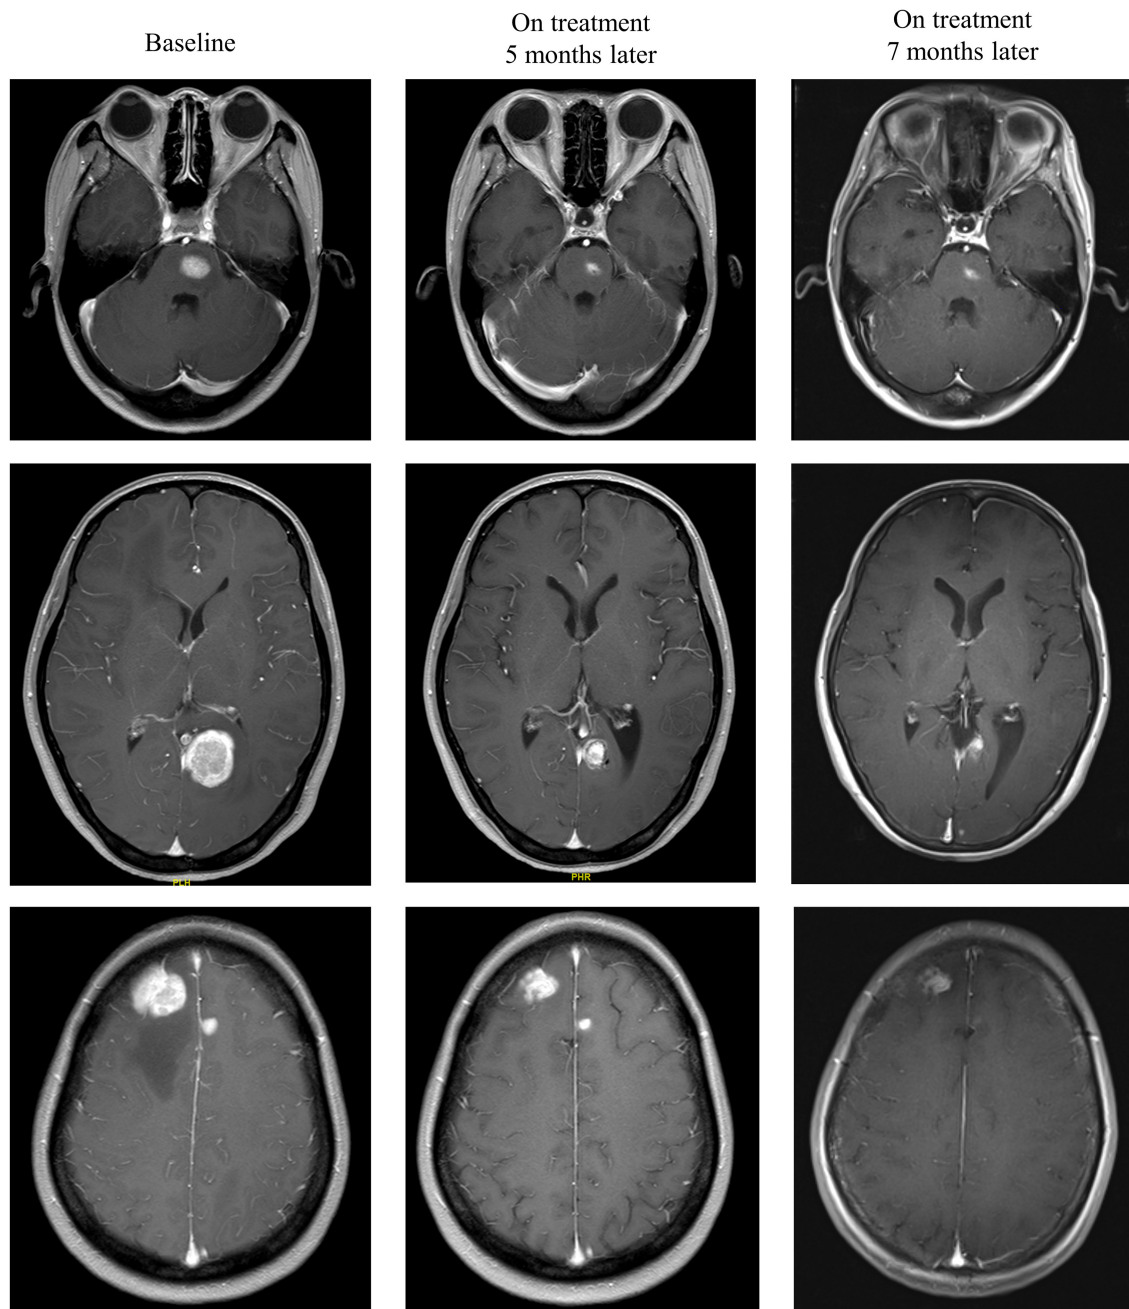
Radiological examples of intracranial partial response. A 33-year-old female diagnosed with multiple melanoma BMs was treated with anti-PD-1 therapy following radiotherapy. MRI images show a partial response 5 months later.
